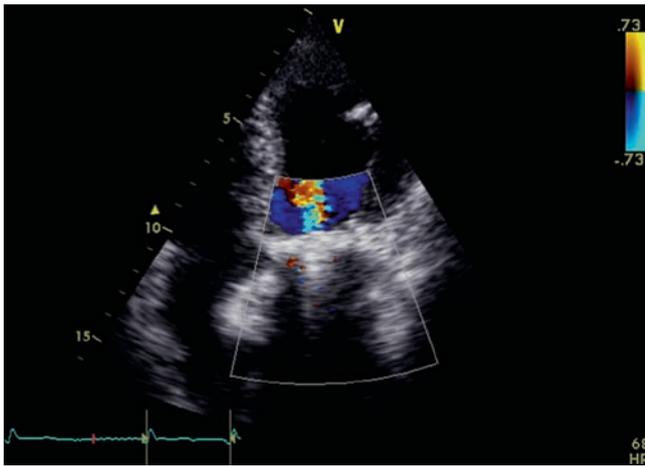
Single-tilting-disc valve obstruction. Colour Doppler echocardiography shows only one anterograde jet
